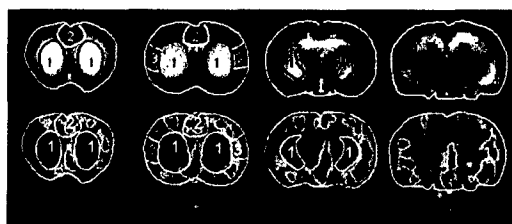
Regions of the interest were drawn on the coronal MR images (striatum = 1; cingulate = 2; S1/S2 cortex = 3) and then overlaid with PET images. The PET data used for quantification was averaged from the areas on the left and right side.
